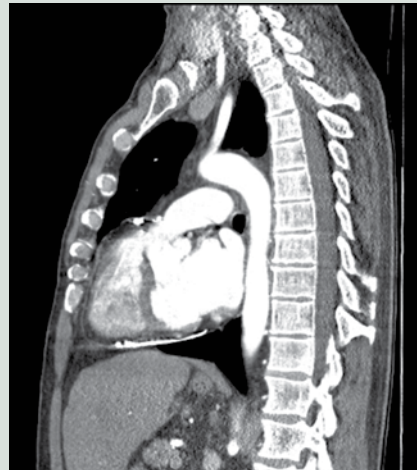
Sagittal view of CT scan showing marked pericardial calcification caused by recurrent pericarditis.
